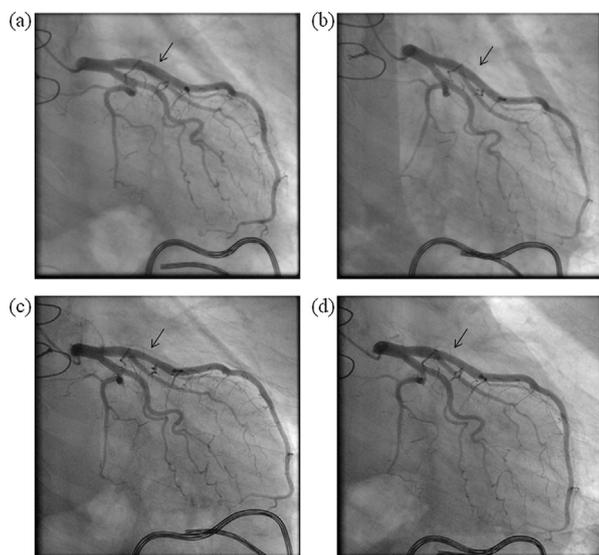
Serial changes in angiogram for left coronary artery after heart transplantation. No obvious stenosis on the coronary artery tree was observed following intracoronary injection of nitrate after heart transplantation at (a) 3 months, (b) 1 year, (c) 2 years, and (d) 3 years, even though increased plaque thickness was detected up to 2 years, as assessed by intravascular ultrasound (IVUS). Arrows indicate the site corresponding to plaque progression and regression observed by IVUS.
